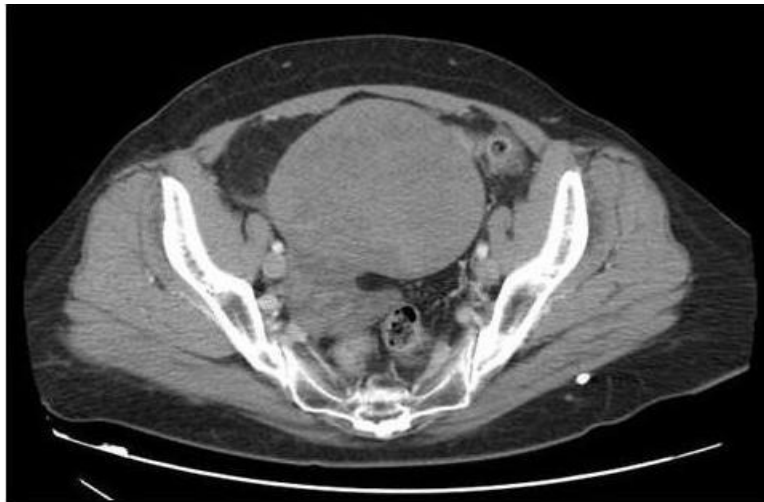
Computed tomography showing the twisted ovarian fibroma (our case).
